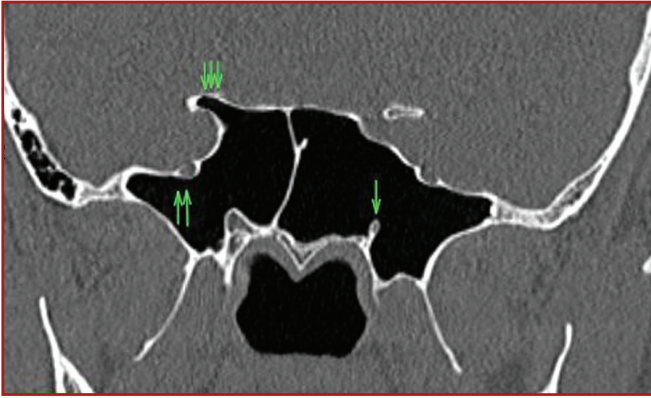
Vidian canal protrusion (arrow) on coronal CT. Note that maxillary nerve dehiscence (double arrow) and pneumatization of the anterior clinoid process (triple arrow).
